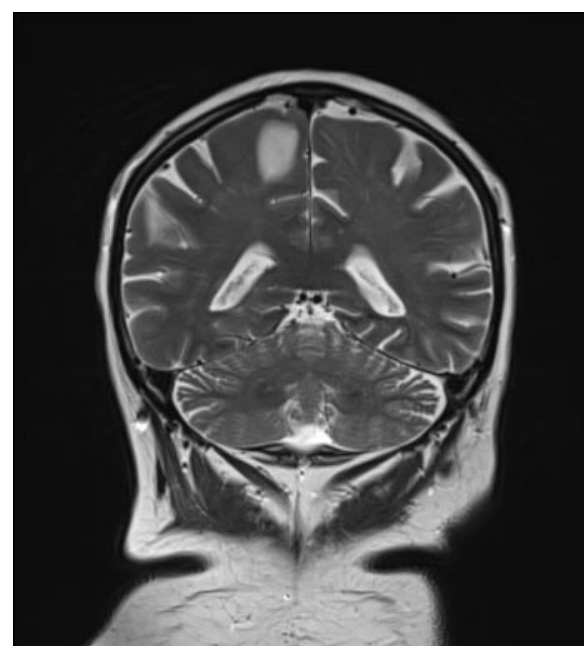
Hyperdense cysticercus of *T. solium* in the brain's right parietal lobe. Magnetic resonance imaging (MRI). The authors' collection.
